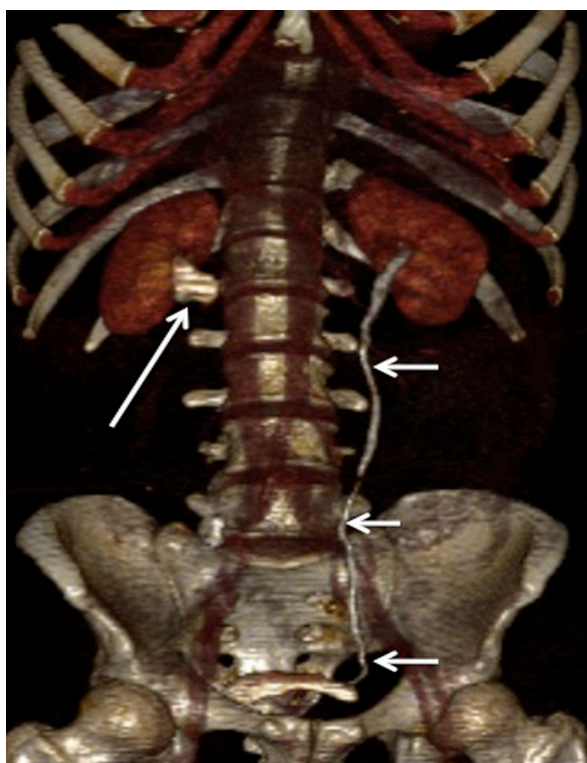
A 3-dimensional reconstruction image from the excretory phase of computed tomography showing the normal course and calibre of the left ureter (short arrows). However, the right ureter was not visualised due to inadequate opacification and contrast filling. The contrast is seen pooling in the dilated right renal pelvis and proximal ureter (long arrow).
